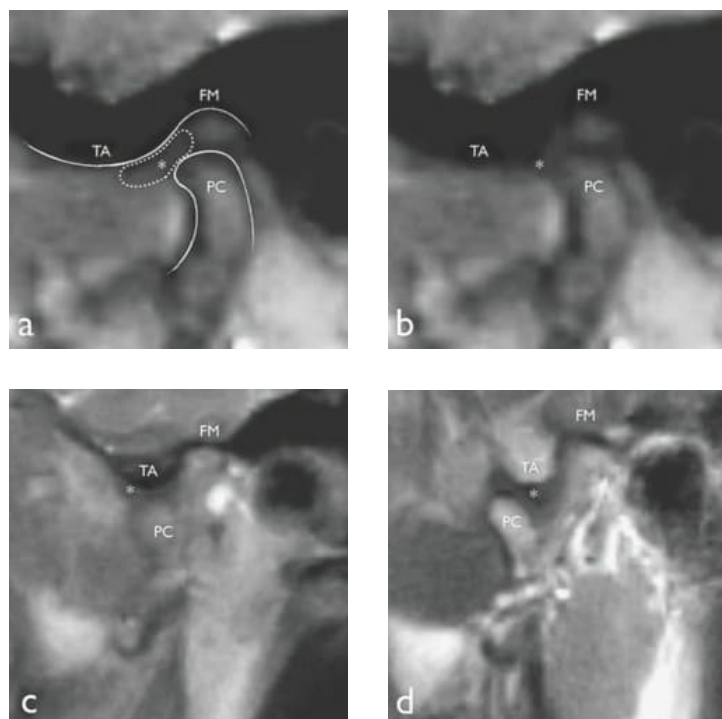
Selected frames from real-time MRI films during mouth opening at intercuspal position (ICP) with markings of the joint surfaces (a), at ICP without markings (b), at about half-open mouth (c), and at maximum open mouth (d). TA = tuberculum articulare; FM = fossa mandibularis; PC = condyle; * = articular disc.
